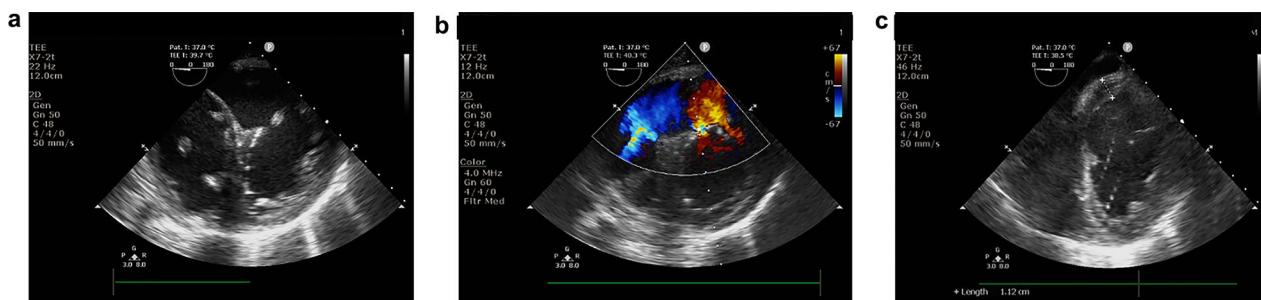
TEE of the parasternal short-axis view on the 25th day after AMI. a 2D image revealed a false lumen with multiple lacerations on both the left and right ventricular sides. b CDFI revealed the left-to-right shunting through multiple lacerations on both the left and right ventricular side of the false lumen. c 2D image revealed hyperechogenicity in the interventricular septum
